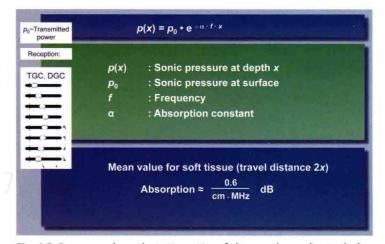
Frequency-dependent attenuation of ultrasound according to the law of absorption. DGC, depth gain compensation; TGC, time gain compensation. (Courtesy of Siemens AG.)
